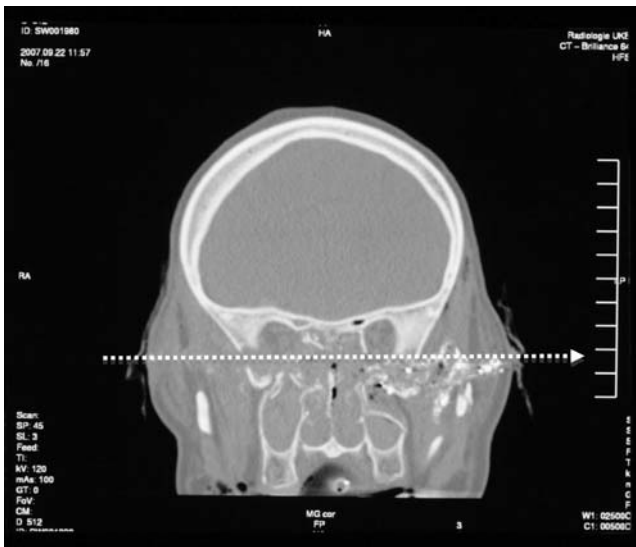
CT scan showing midfacial destruction after a suicide attempt
